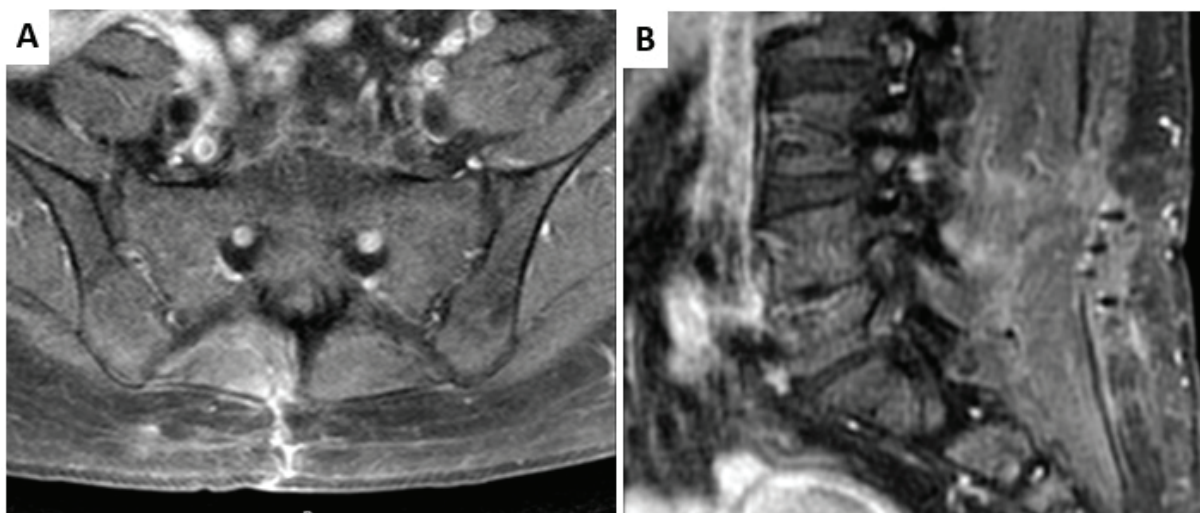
(A, B): Axial and sagittal T1-weighted MRI sections show that the postoperative lesion area.
